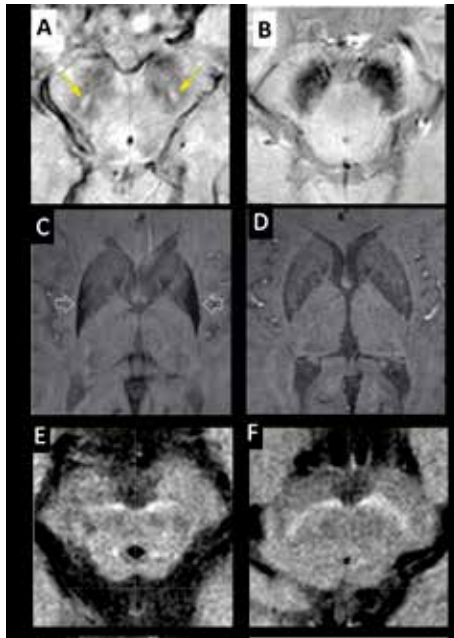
Advanced MRI techniques used in the diagnosis and follow up of parkinsonism.
